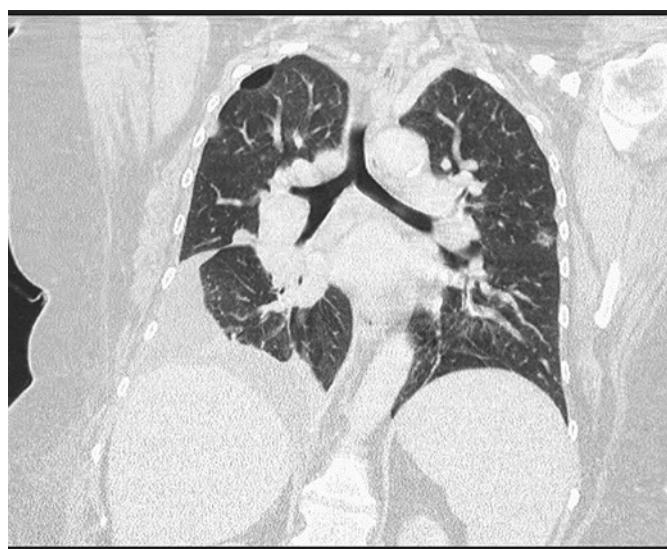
CT chest: bulky bilateral hilar and mediastinal adenopathy and loculated pleural fluid located posterolaterally on the right.
